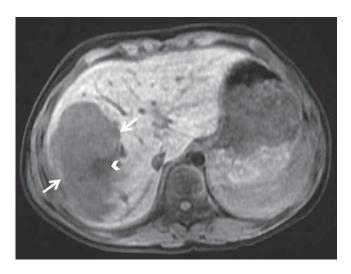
Axial T1-weighted image shows hypointense tumor with lobulated margin (arrows) and cystic-necrotic area in the central part of the tumor (arrowhead).
